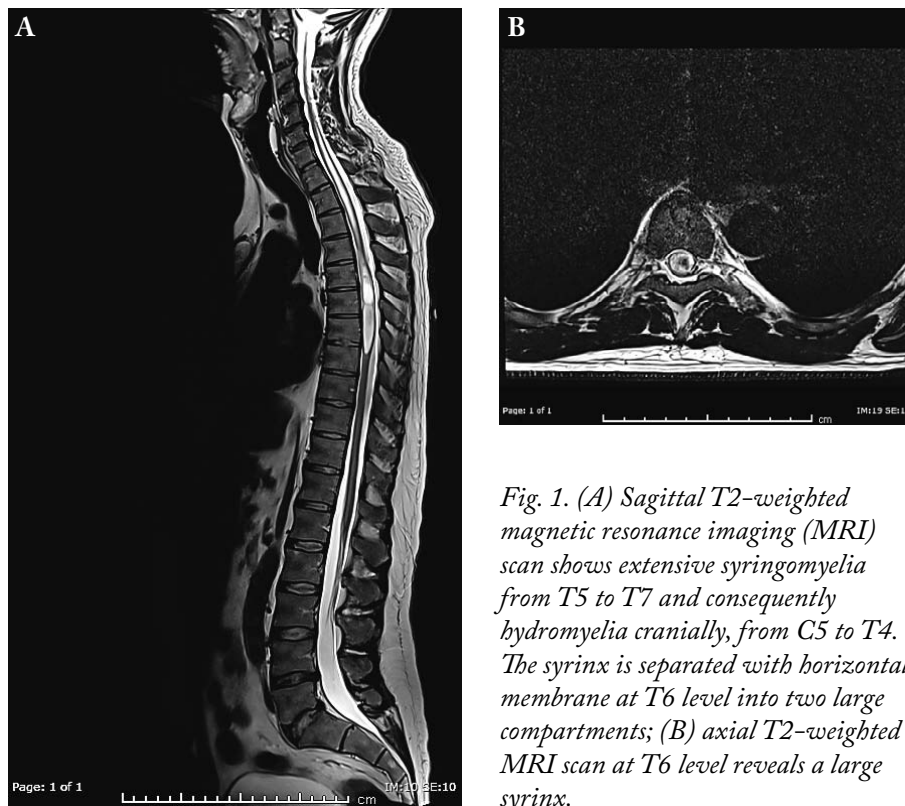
(A) Sagittal T2-weighted magnetic resonance imaging (MRI) scan shows extensive syringomyelia from T5 to T7 and consequently hydromyelia cranially, from C5 to T4. The syrinx is separated with horizontal membrane at T6 level into two large compartments; (B) axial T2-weighted MRI scan at T6 level reveals a large syrinx.
